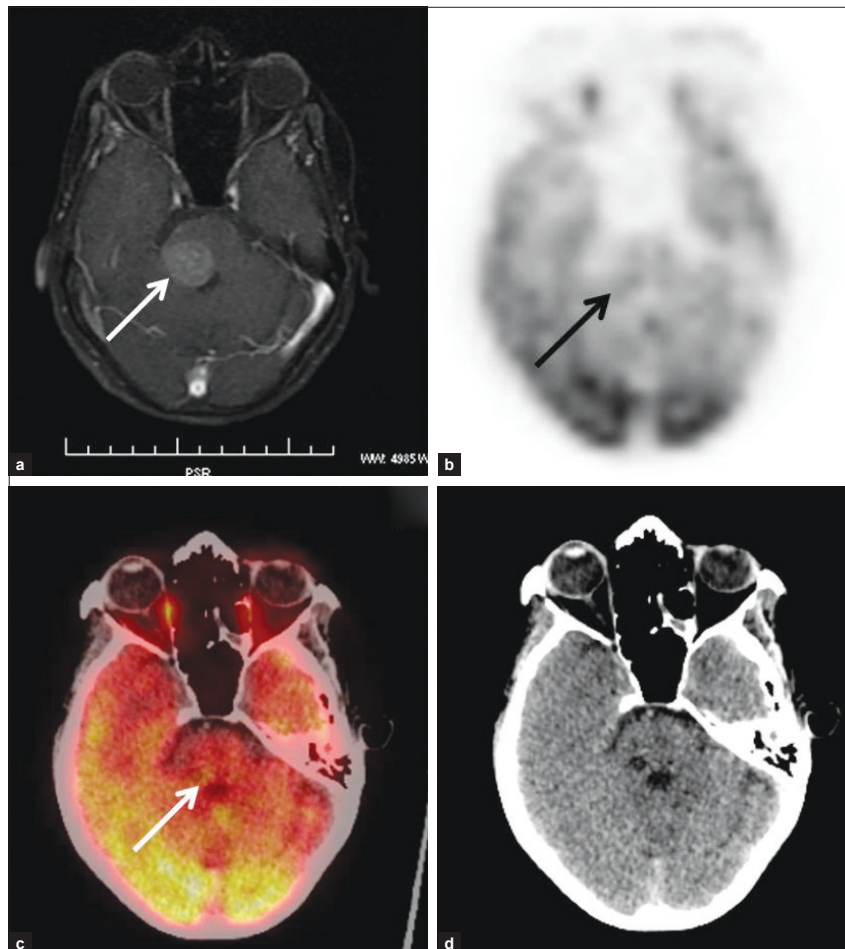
Operable case of lung cancer for preoperative staging for brain metastases. Contrast enhanced T1 W axial MRI (a) shows a well-defined enhancing metastatic lesion in the pons (arrow). Lesion is not appreciated on axial PET (b) and fused PET/CT images (c and d)
